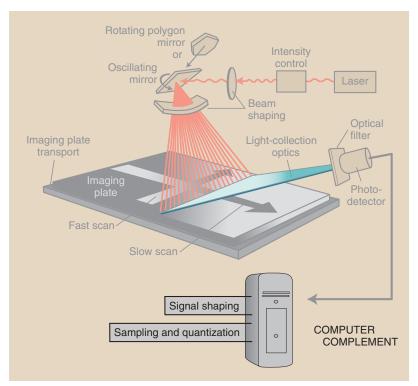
The computer complement to a computed radiography (CR) reader provides signal amplification, signal compression, scanning control, analog-to-digital conversion, and image buffering.
